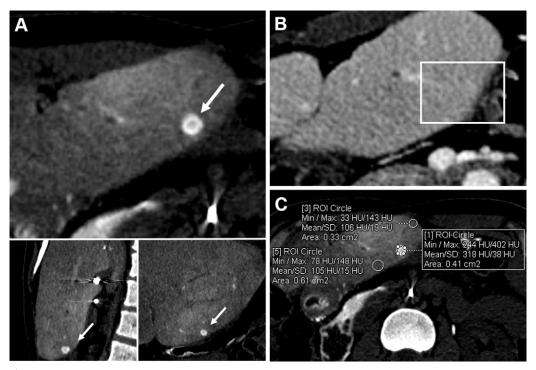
Images in a 42-year-old woman who underwent ablation for colorectal liver metastases with an incidental RHLM (size: 8 mm). (A) Axial CTHA image shows the incidental RHLM (arrows), which is also visible in the other two orthogonal planes (insets). (B) Incidental RHLM was not detected on baseline axial CT image during portal venous phase obtained 9 days prior to procedure (inset). (C) Axial CTHA image exemplifies ROI-based quantitative analysis. The image shows *ROI*Tumor (circle with higher attenuation) with a mean Hounsfield unit of more than two times higher (318 vs 105.5 HU) than the *ROI*liverparenchyma (circles with low attenuation). CTHA = CT during hepatic arteriography, HU = Hounsfield units, RHLM = ring-hyperenhancing liver micronodule, ROI = region of interest.
